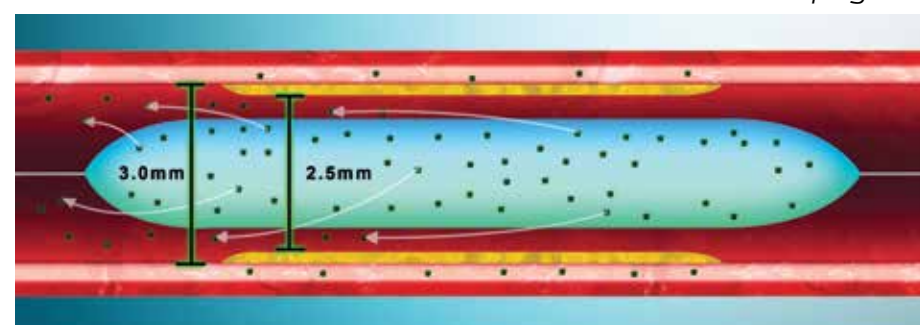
Appropriate sizing is crucial for the following reasons: an undersized DCB has many unfavorable implications including drug/excipient distal and local embolization and an undersized balloon with a large drug-coated surface area, in a hostile environment of high flow velocity coupled with turbulent flow, and irregular plaque morphology increases risk of distal embolization. To avoid such implications one should utilize fluoroscopy, intravascular ultrasound and extravascular ultrasound to insure proper sizing.
